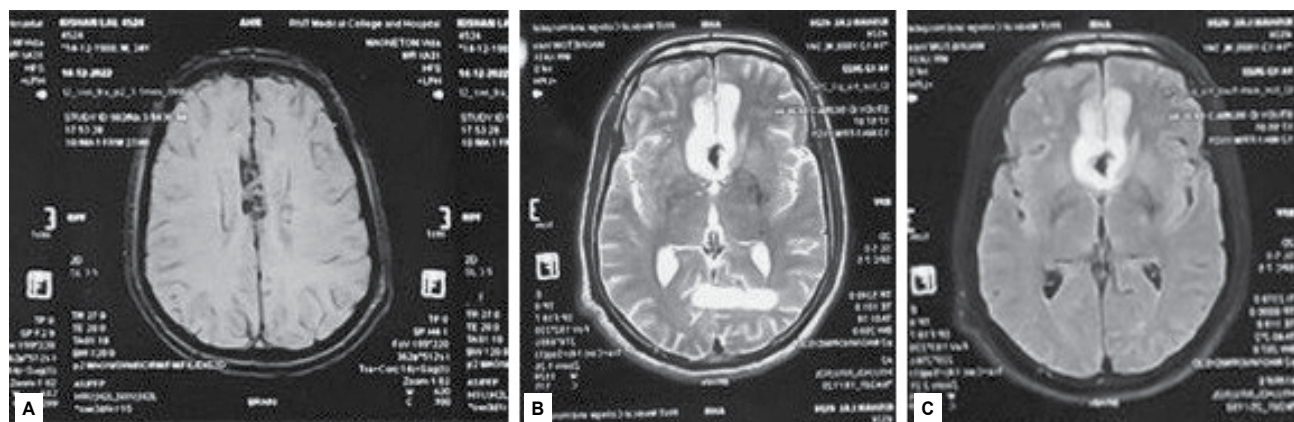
SWI Image shows blooming along parafalcine location (A). T2W (B) and FLAIR (C) images show hyperintensity involving cortical as well as subcortical white matter in bilateral parafalcine frontal location.
